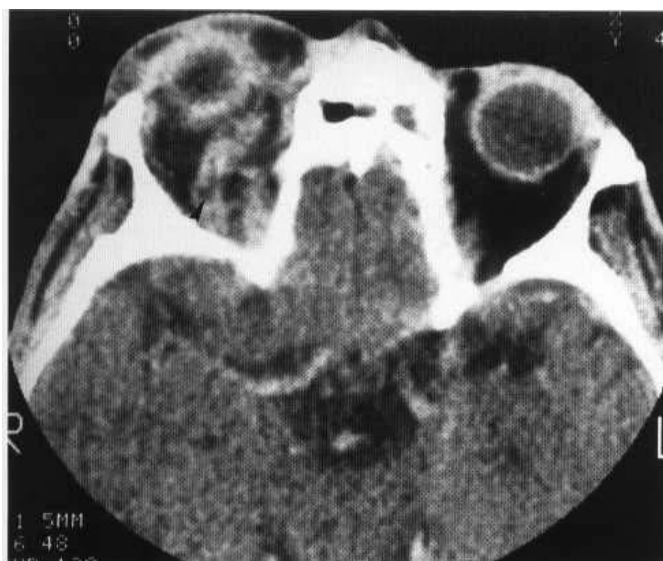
CT scan showing infection in the sinuses with orbital cellulitis and superior ophthalmic vein thrombosis (arrowhead).
